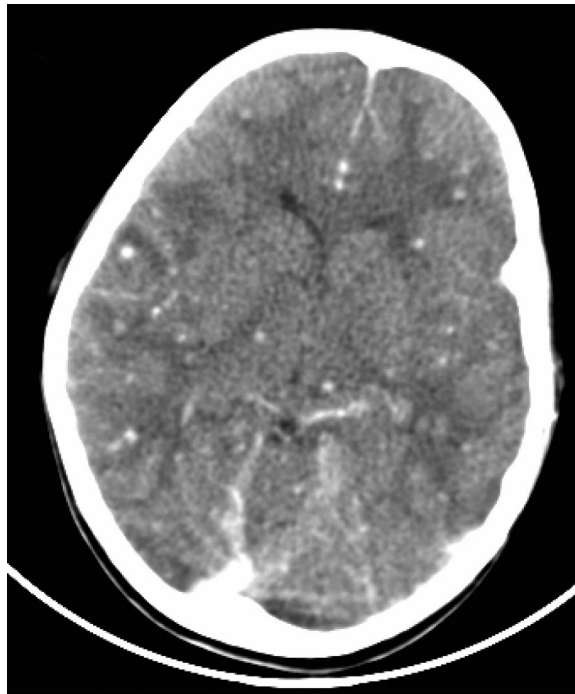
Contrast enhanced computed tomography (CT) brain scan showing numerous, subcentimetre, nodular enhancing lesions.
